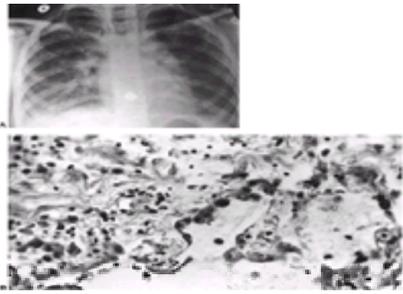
Cytotoxic pulmonary damage secondary to busulfan in the immunocompromised patient. (A) Chest roentgenogram shows diffuse alveolar-interstitial infiltrates. (B) Lung biopsy demonstrates inflammatory changes, fibrosis, and hypertrophy of alveolar lining cells following busulfan therapy.
